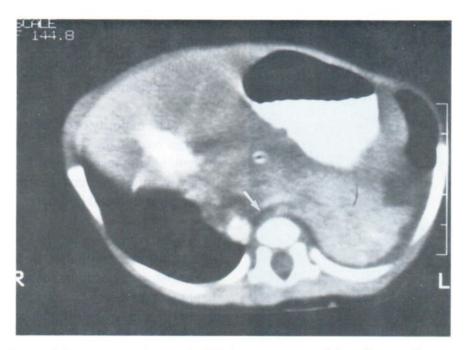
Axial contrast-enhanced CT demonstrates origin of anomalous artery from the abdominal aorta. (arrow)
